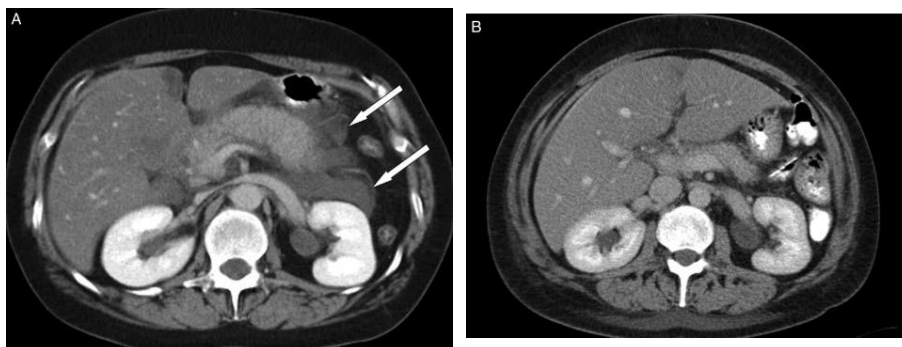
(A) Acute interstitial oedematous pancreatitis and acute peripancreatic fluid collection (APFC) in the left anterior pararenal space on CT (white arrows showing the borders of the (APFC) in a 38-year-old woman. The pancreas enhances completely, is thickened, and has a heterogeneous appearance due to edema. APFC has fluid density without an encapsulating wall. (B) A few weeks later, a follow up CT shows complete resolution of the APFC with minimal residual peripancreatic fat stranding (Bharwani et al., 2011).
